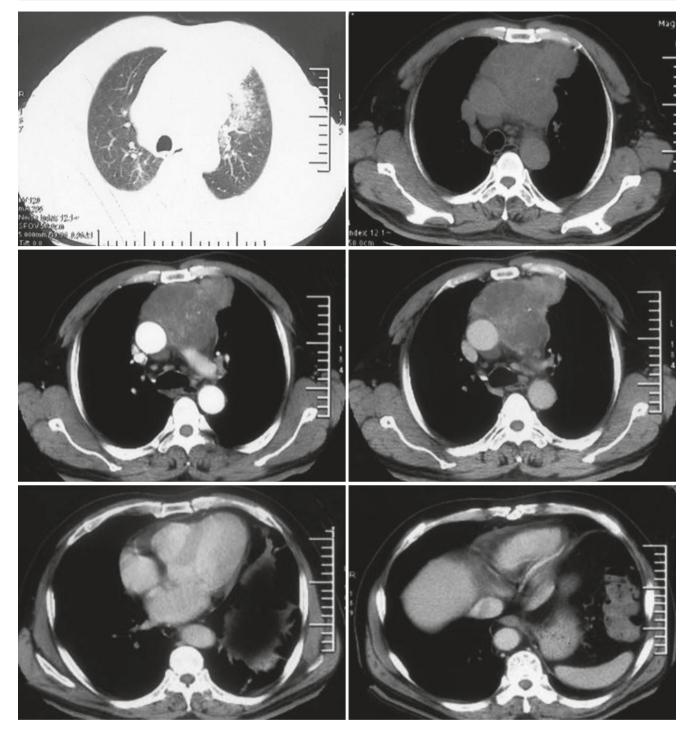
Chest CT images of a 59-year-old man complained of dry cough for 2 weeks
